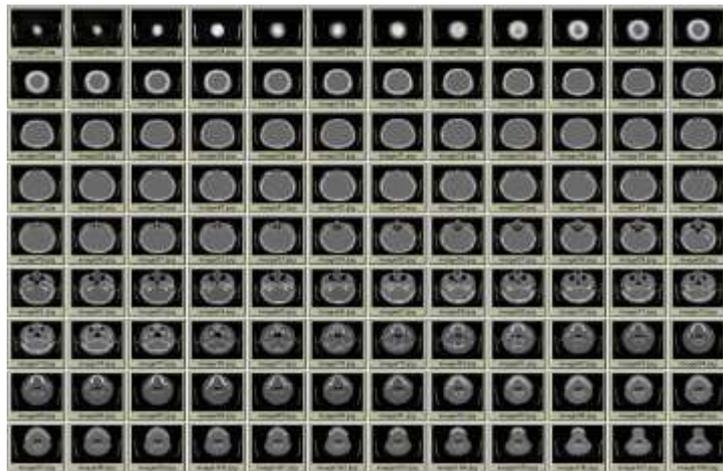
Stack of slice images from CT scan in 2D dicom format
